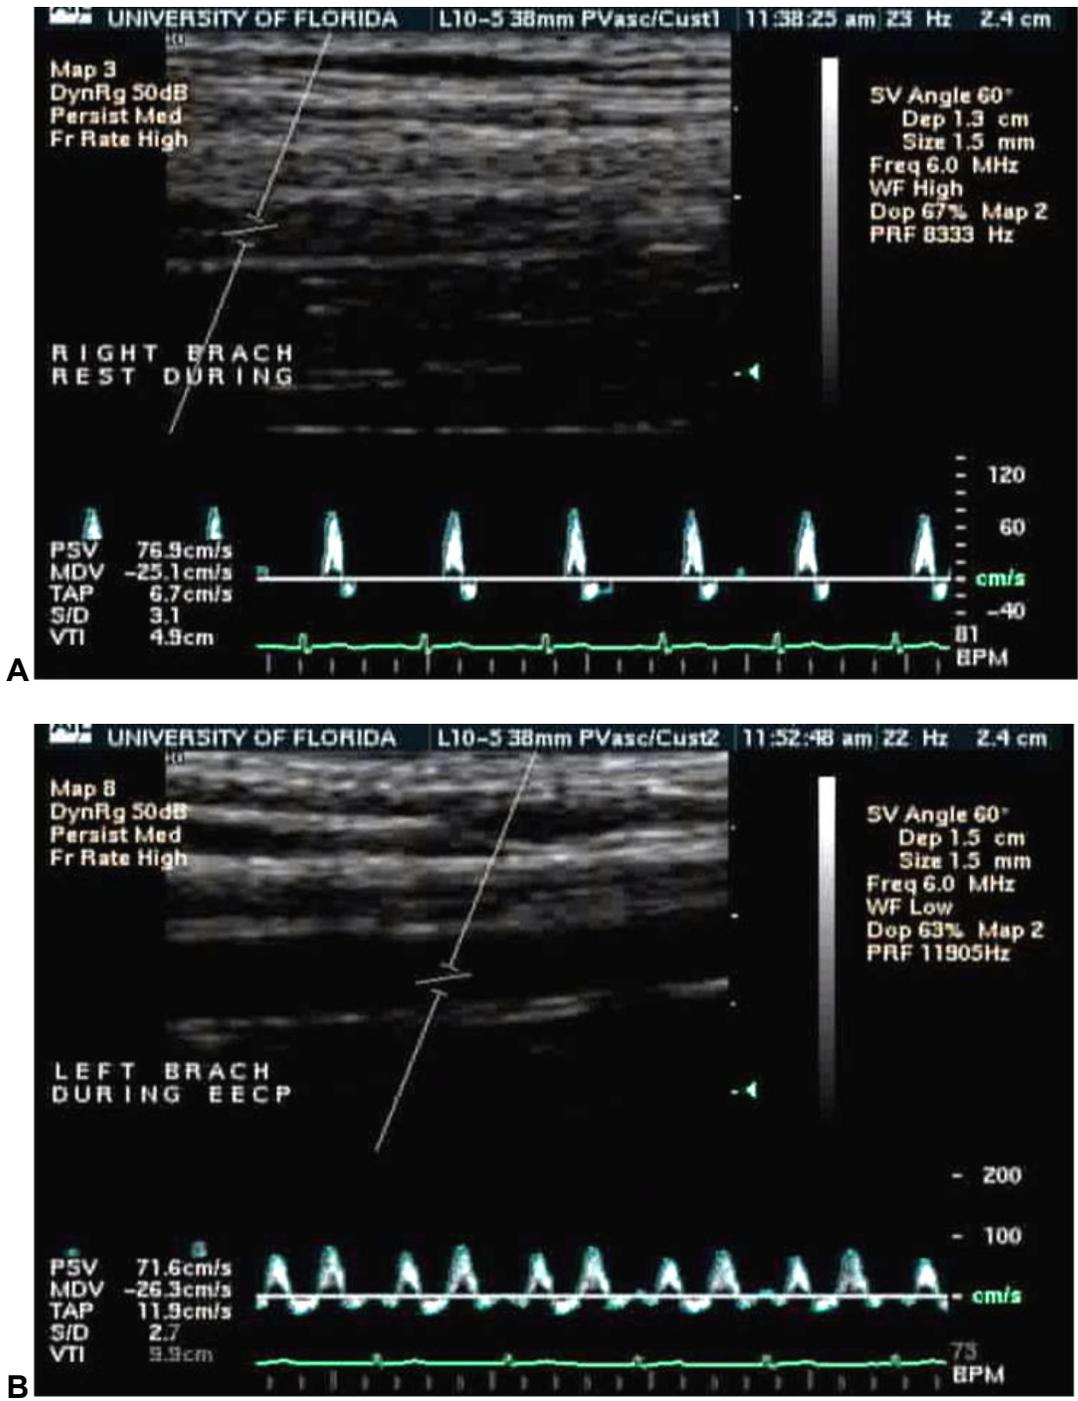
High definition ultrasound pictures and Doppler spectrum of the brachial artery during sham (A) and EECP (B).
